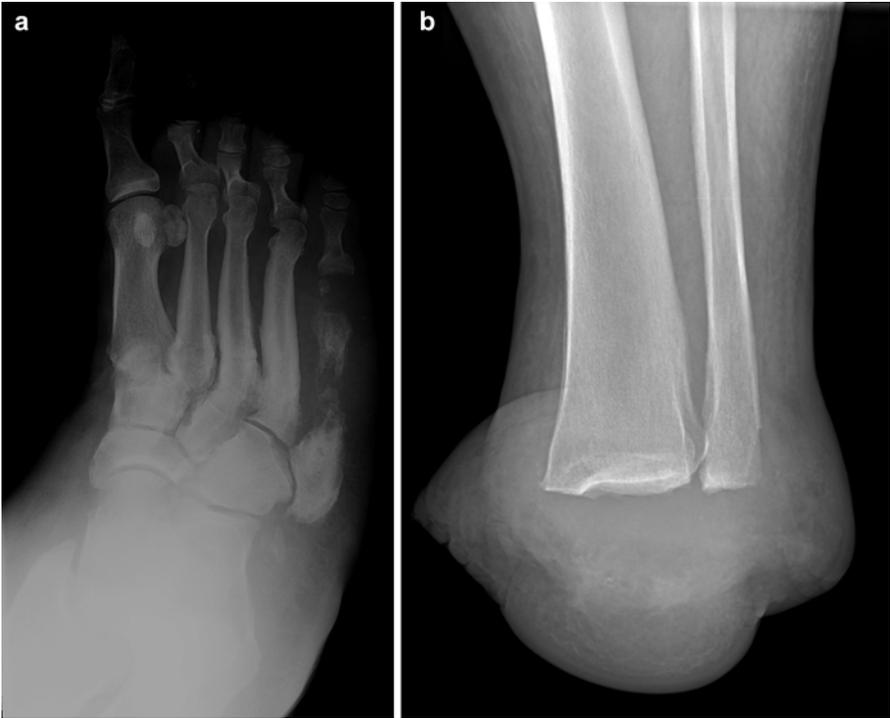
AP radiograph of patient with poorly treated diabetic neuropathy with osteomyelitis of the fifth metatarsal (a). Reconstructive surgery was not possible and a Syme's amputation was performed (b)
